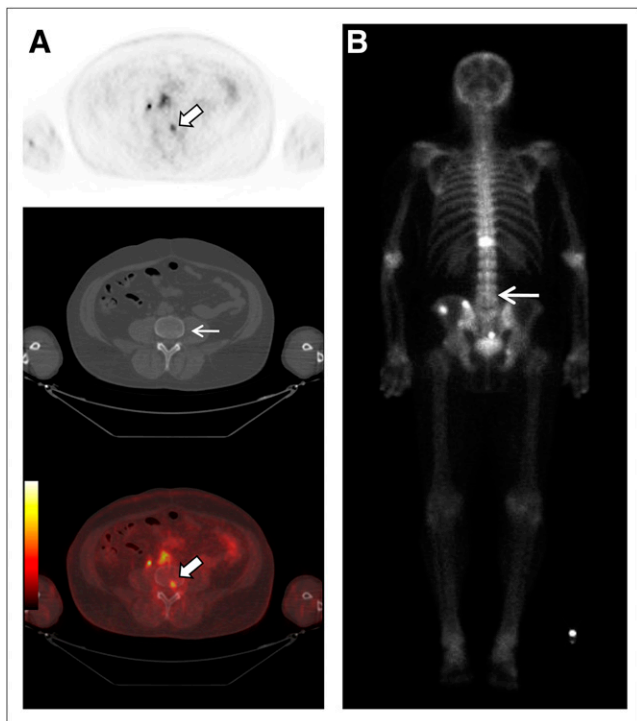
Focal ^{18}F -DCFBC PET uptake in L4 vertebral body on PET and fused PET/CT (thick arrows, A) with no correlative abnormality on CT (thin arrow, A) or bone scan (arrow, B).
